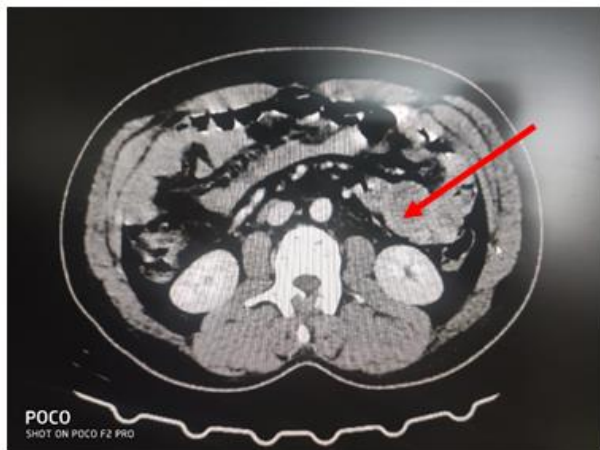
CT image of the hemorrhagic jejunal process "clinical case 2"
